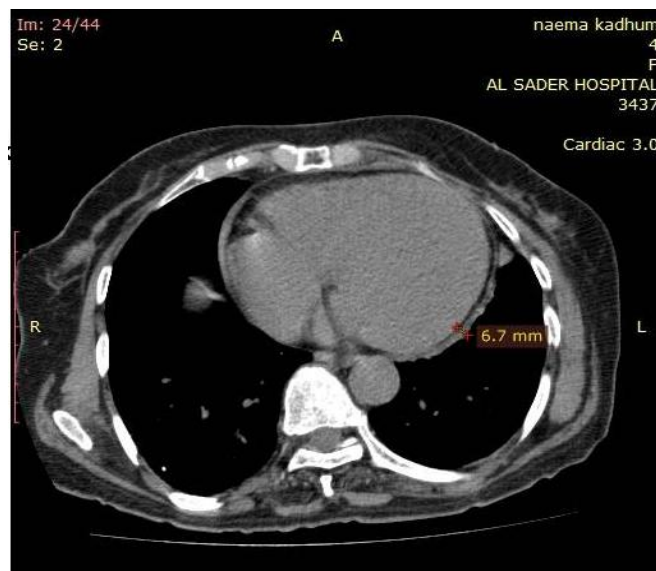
pericardial thickening incidentally detected in 49 -year-old woman who was referred for coronary CT angiography for chest pain and dyspnea .
